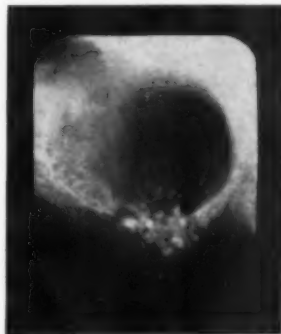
Roentgenogram of cyst showing radiopaque bodies which proved to be an odontoma.
